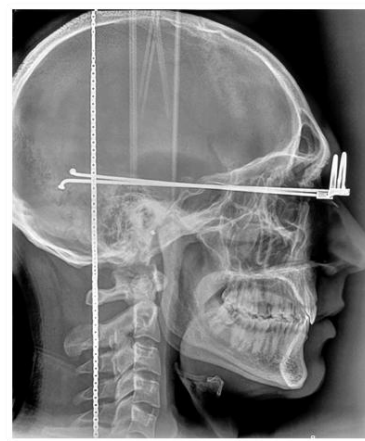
A Lateral cephalometric radiograph with the Orienter in place
